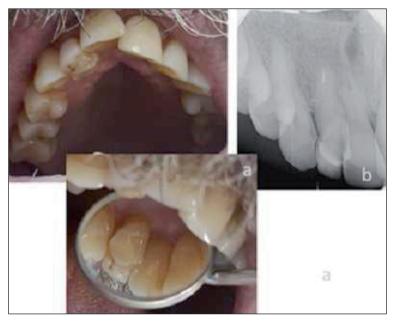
Images of fusion with supernumerary tooth in the lateral incisor of 59-year-old male patient [intraoral photography (a), periapical radiography (b)].
